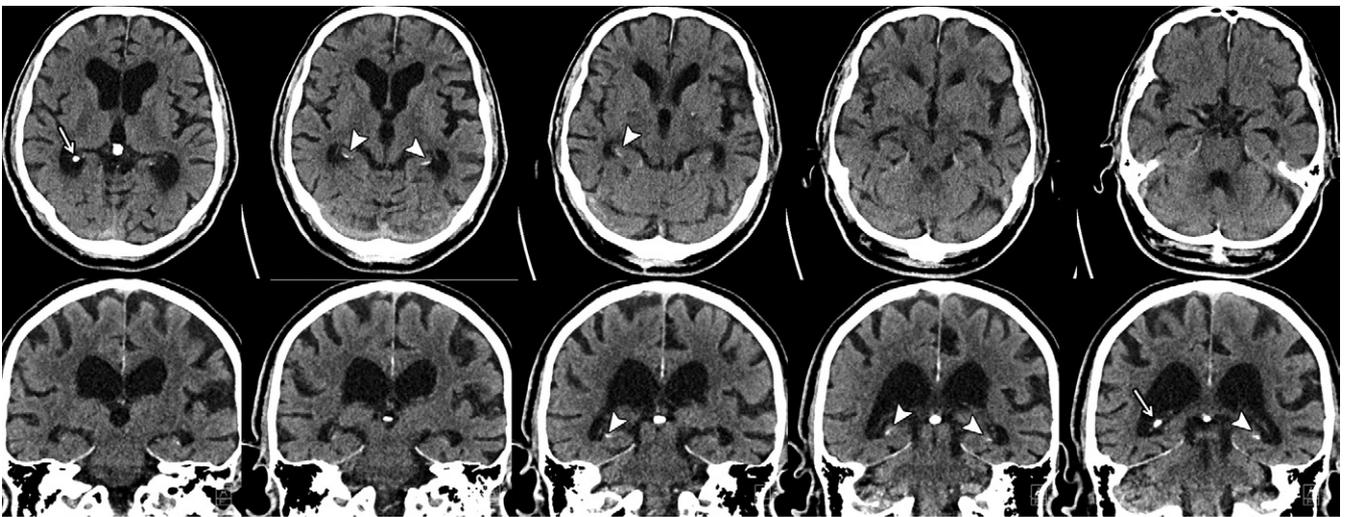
Axial and coronal CT images in 74-year-old woman show moderate hippocampal calcifications (arrowheads). Arrows indicate calcifications of choroid plexus.
